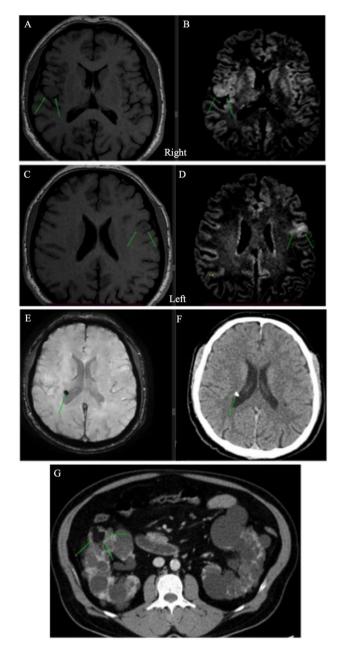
MRI aspect of cortical cerebral tubers- axial slices; T1 native axial in the (A) right and C left frontal lobe; (B) and D ADC sequence; E MRI aspect of a nodular lesion located periventricular with a hypo dense signal in SWI sequence and F CT scan in axial plane showing the calcified periventricular lesion marked by the green arrow; G CT aspect of renal angyomyolipoma-axial slices; the green arrows in the right kidney present a high hypo-dense lesion with an irregular border suggestive of angiomyolipoma
